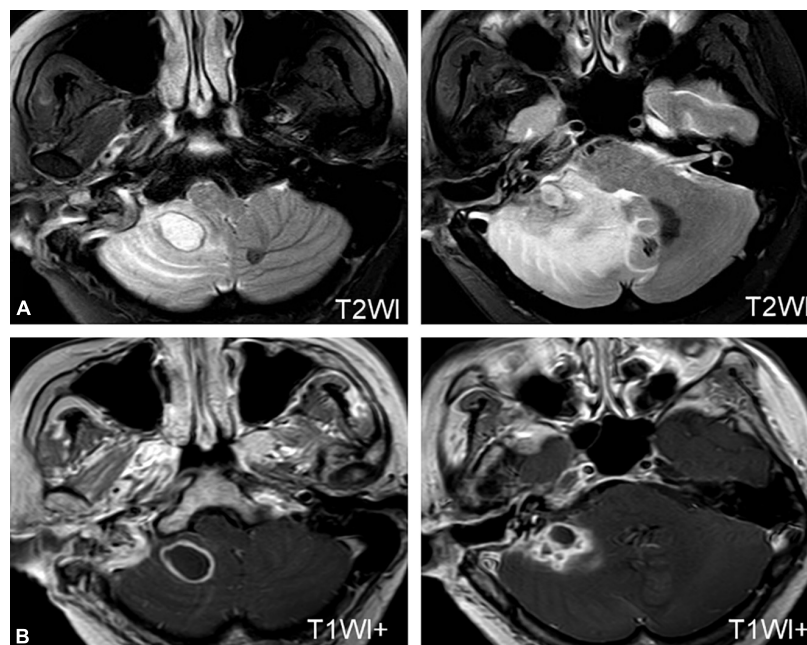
MRI of a patient with a cerebellar abscess. (A) MRI shows an abscess in the right cerebellum. (B) MRI of the patient after neurosurgery.
